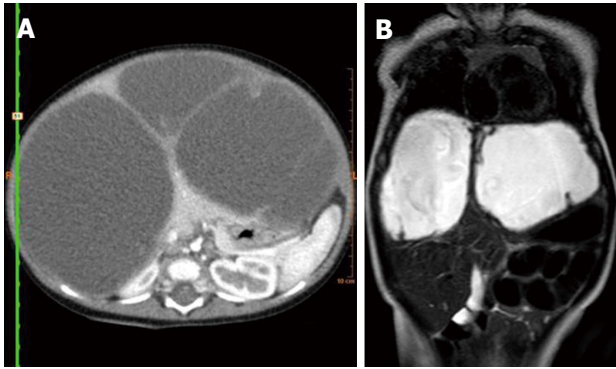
Abdominal computed tomography and magnetic resonance imaging. A: Abdominal computed tomography-contrast shows enhancement of the solid component, septate, and the peripheral rim; B: Abdominal magnetic resonance imaging-contrast shows a high signal intensity on T2-weighted magnetic resonance sequences.
